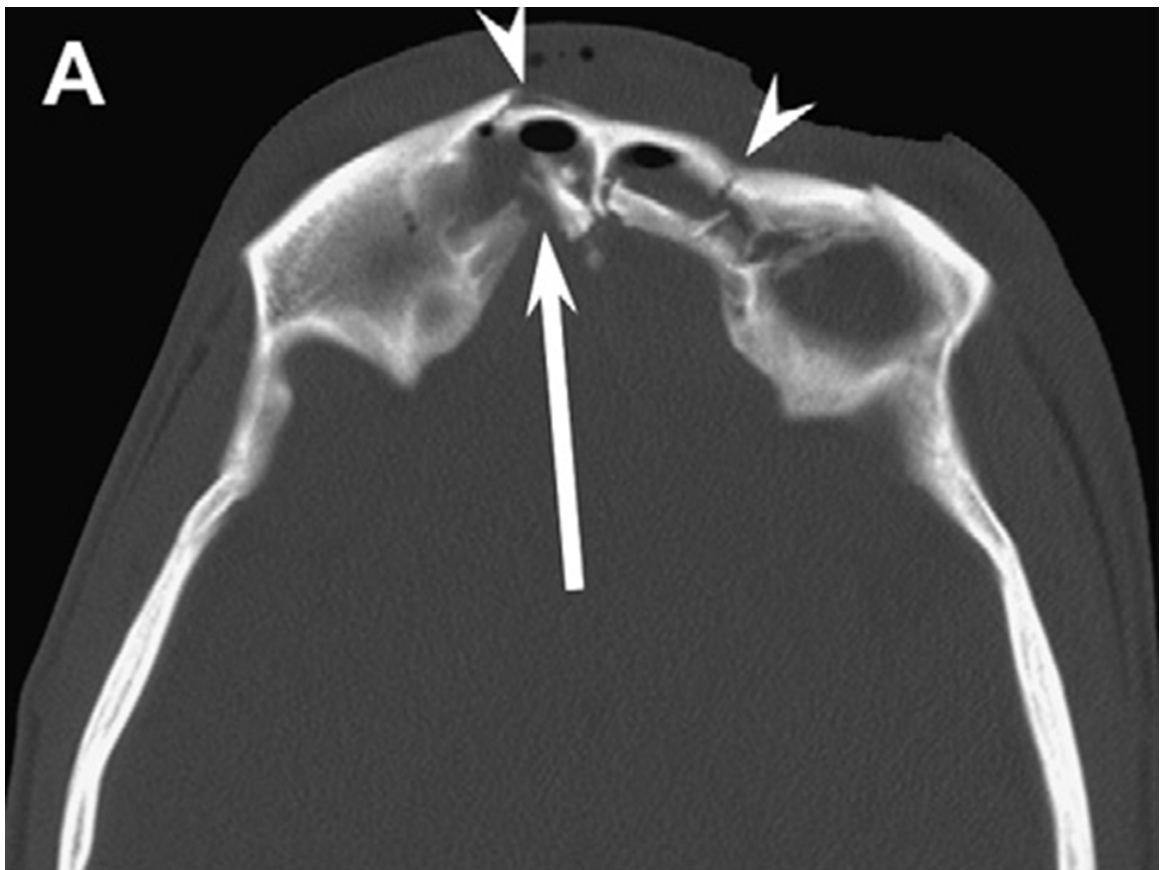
Axial CT scan showing fractures of both anterior and posterior tables of the frontal sinuses.
